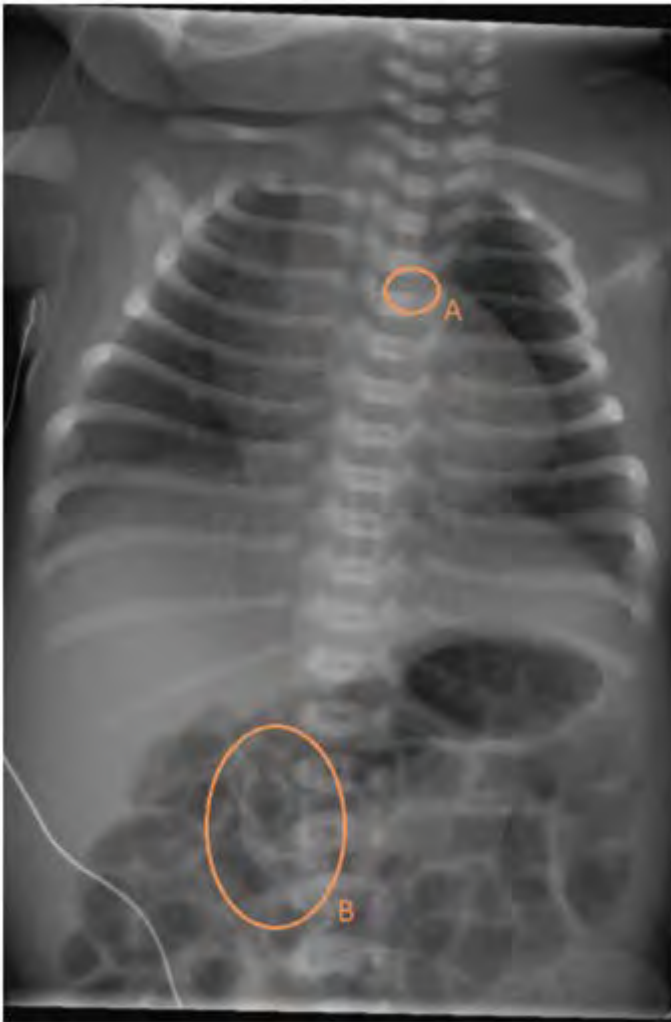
Plain film at 4.5 hours of life. Circle A shows thrombus in the region of the right atrium, and circle B shows the calcified IVC thrombus.
